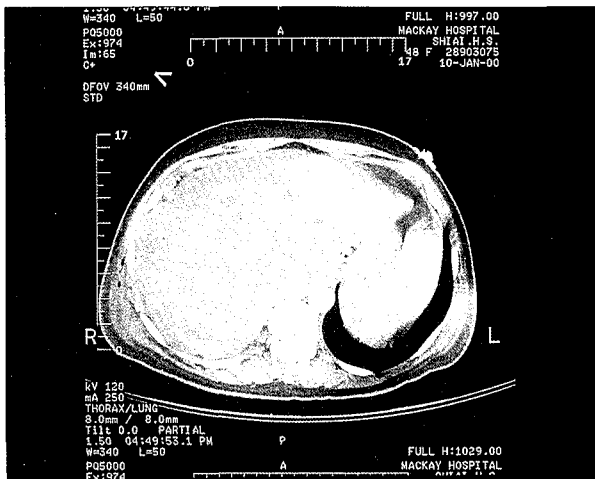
CT scan showing a lobulated mass with heterogeneous density and an area of calcification
